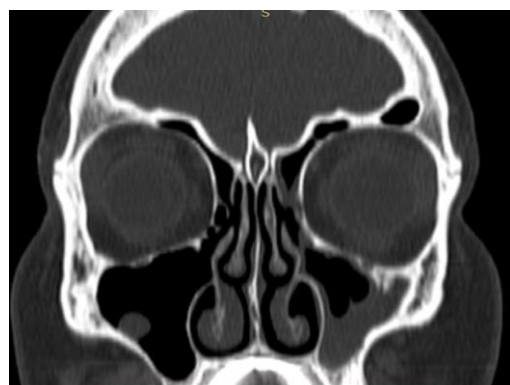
CT scan of the right maxillary sinus demonstrating soft-tissue opacities consistent with polyp, CT scan of the left maxillary sinus demonstrating partial opacification and associated ostiomeatal complex narrowing, consistent with chronic inflammatory changes. (CT Image provided by Dr. A. Gharibyan)
